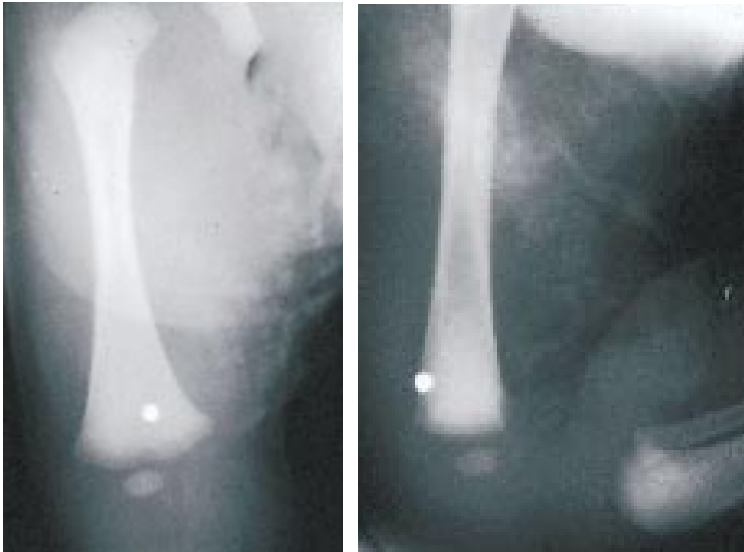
After delivery of the infant, radiography showed the presence of the BB pellet at the distal end of the femur. The infant had a normal course.
